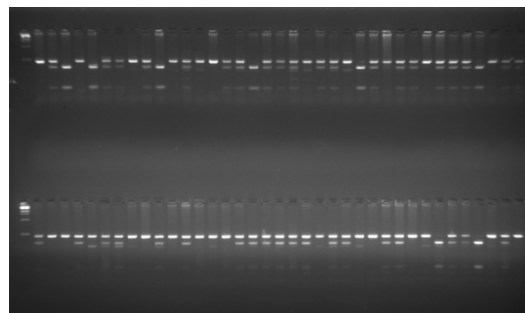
Electrophoresis pattern for ABCB1 C3435T alleles analyzed by PCR-RFLP. Homozygous wild type CC (172bp, 60 bp, 16 bp), heterozygous CT (248 bp, 172 bp, 60 bp,16 bp). homozygous variant type TT (248 bp).
